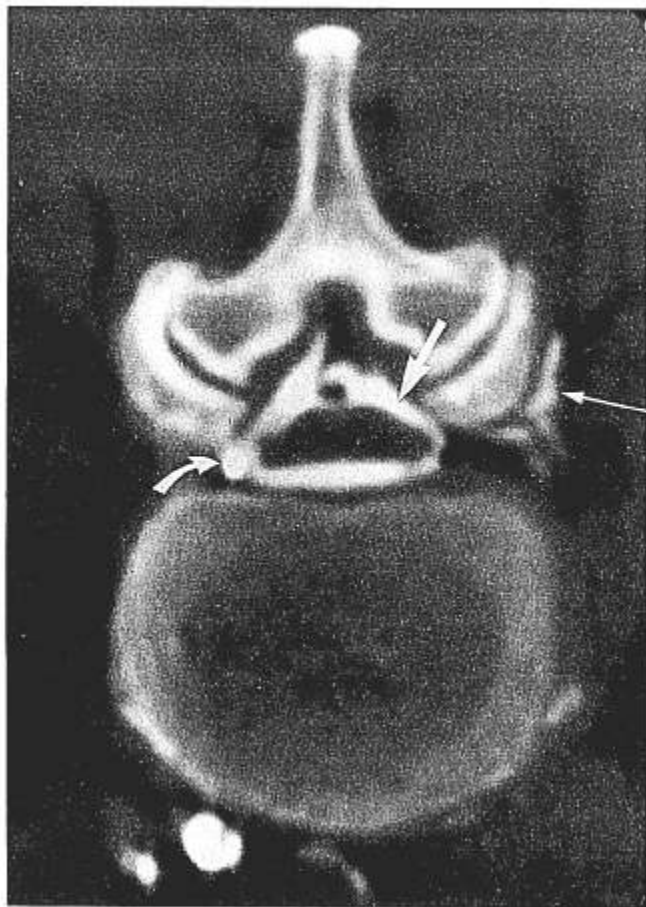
Axial computerized tomography (CT) image at the third lumbar level showing contrast material (heavy straight arrow) encircling and compressing the dura and suspending the posterior epidural fat. An air bubble appears posterior to the dura, and lateral passage through the nerve root canal is evident (thin straight arrow), as is the epidural catheter (curved arrow). Adjacent CT images showed the contrast material to be continuous along the epidural space without gaps at the vertebral laminae.
